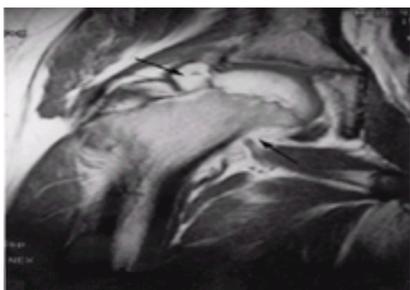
Tuberculosis of the hip in an 11-year-old boy. Enhanced T_1 -weighted MR image shows a non-specific intense enhancement of a dramatic synovial proliferation in the right hip (arrow).
